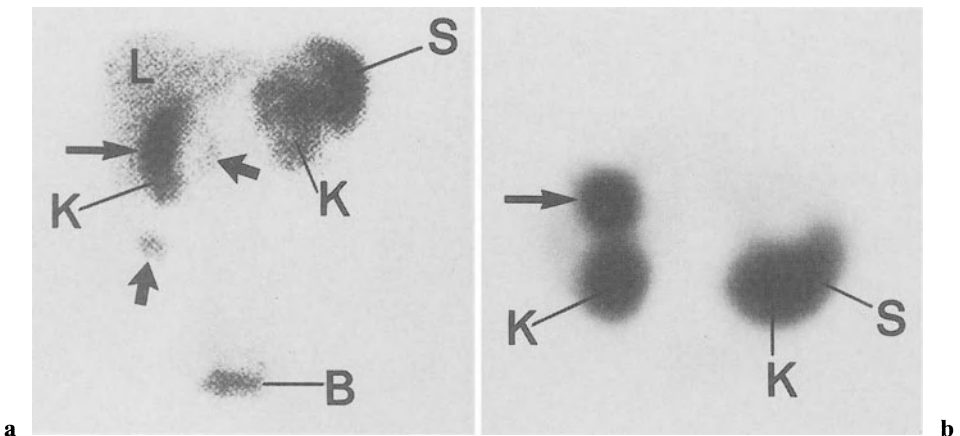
Anterior somatostatin receptor scintigraphic view of a midgut carcinoid (a) shows primary tumor (*short arrow*) and a questionable area in projection to the right kidney (*long arrow*). The transversal slices of single photon emission computed tomography (b) clearly show a liver metastasis (*long arrow*) in front of the right kidney. L, liver; S, spleen; K, kidney; B, bladder
